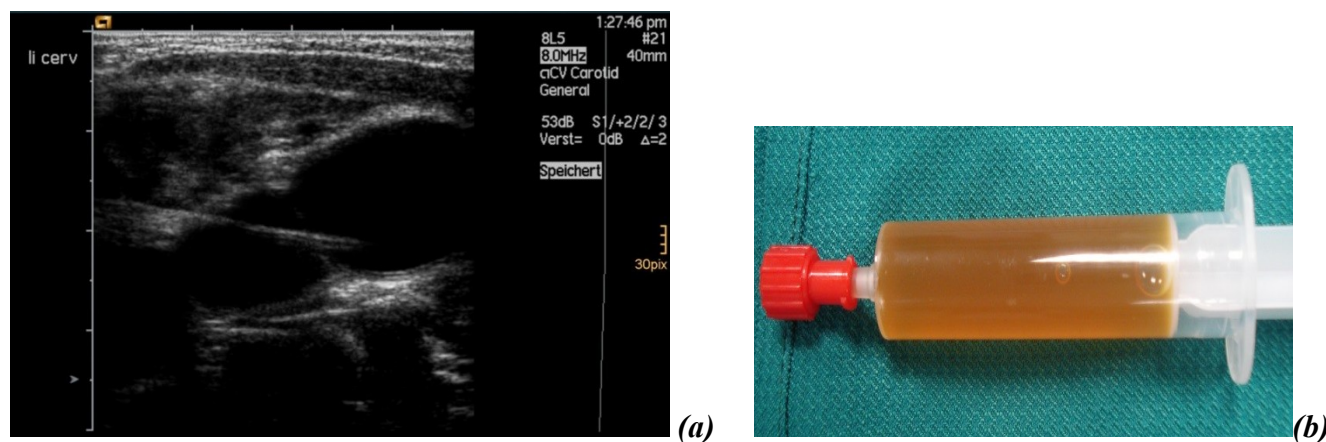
Ultrasound injection of OK -432 into lymphangioma (a), after aspiration (b)
